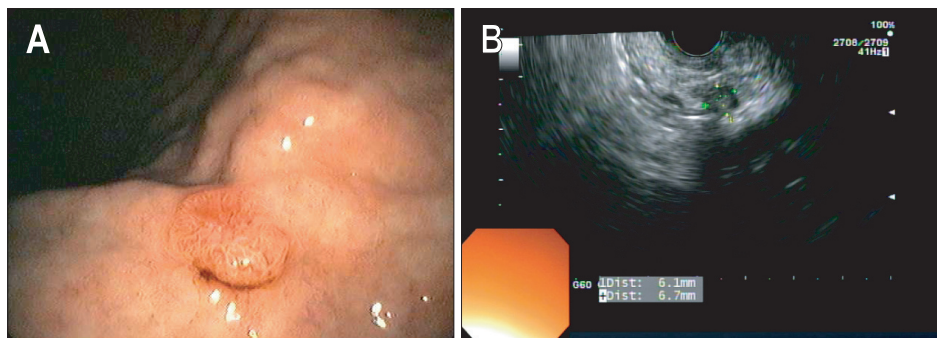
(A) Endoscopic image of a gastric neuroendocrine tumor (NET). (B) Endosonographic image of a small pancreatic NET, measuring 6×7 mm.
